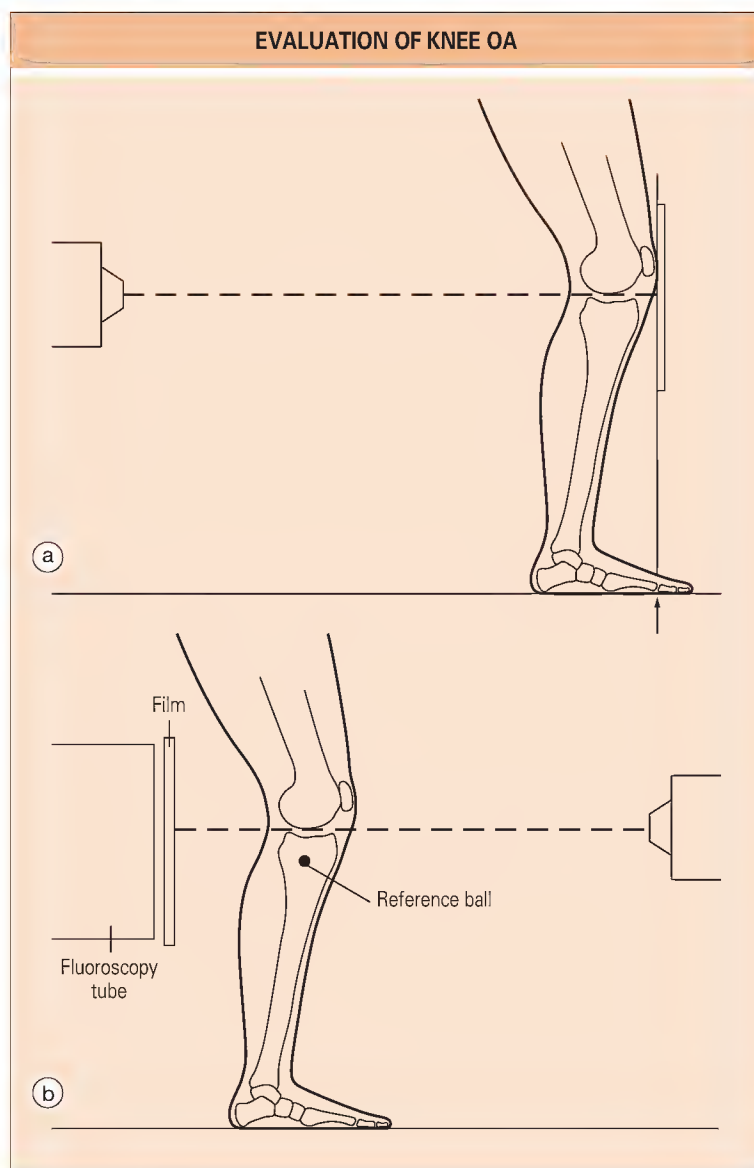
Reproducible radiographic methods for reliable evaluation in knee osteoarthritis (OA). (a) The patient stands in the semiflexed position; both knees are bent and in contact with the film cassette, and the feet are slightly externally rotated (about 15 degrees). The first metatarsophalangeal joint of each foot (arrow) is positioned immediately below and in line with the front edge of the film cassette. The x-ray beam is directed midway between the knees, and the tube's positioning light is aligned with the horizontal plane of the joint. (b) The knee can also be positioned reproducibly in the semiflexed view by using fluoroscopy to position the tibial plateau horizontally and parallel to the x-ray beam. A metallic reference ball is used to correct for radiographic magnification.
